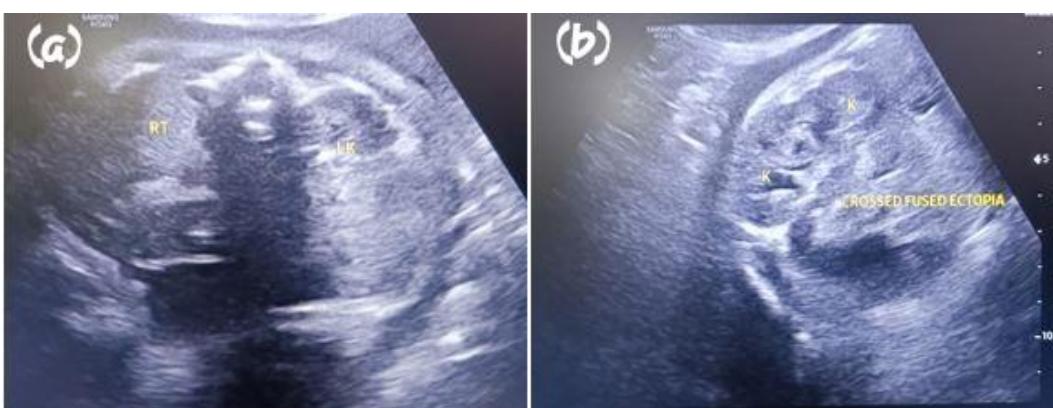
and 2b shows Antenatal ultrasound images demonstrating an empty right renal fossa (a) with a crossed fused renal ectopia identified on the left side (b).
